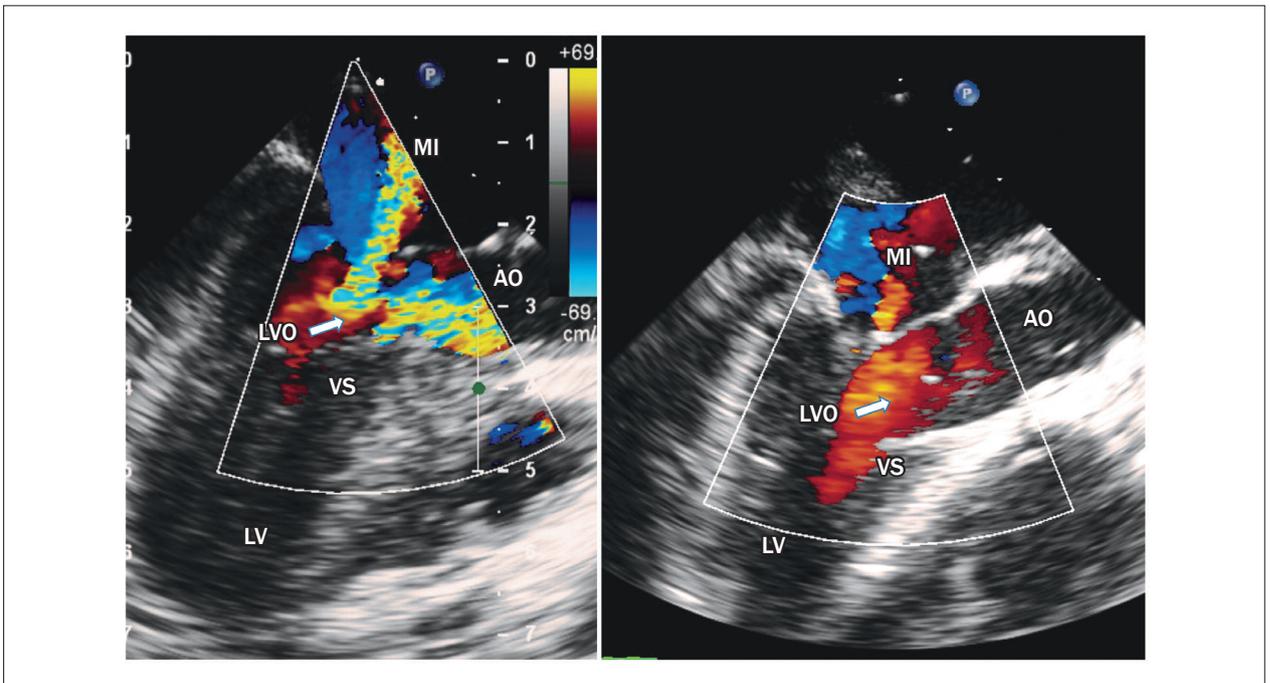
Intraoperative transesophageal echocardiogram before and after off-pump cardiopulmonary bypass (CPB). LV: left ventricle; VS: interventricular septum; AO: aorta; LVO: left ventricular outflow tract; MI: mitral insufficiency.
